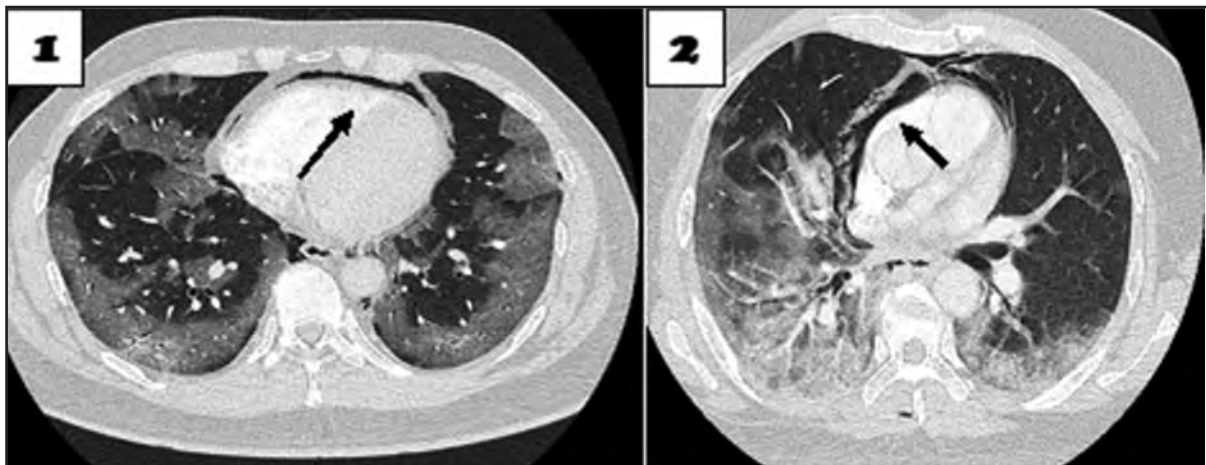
CT pulmonary angiogram of case 1 and 2 respectively showing pneumomediastinum and pneumopericardium.
